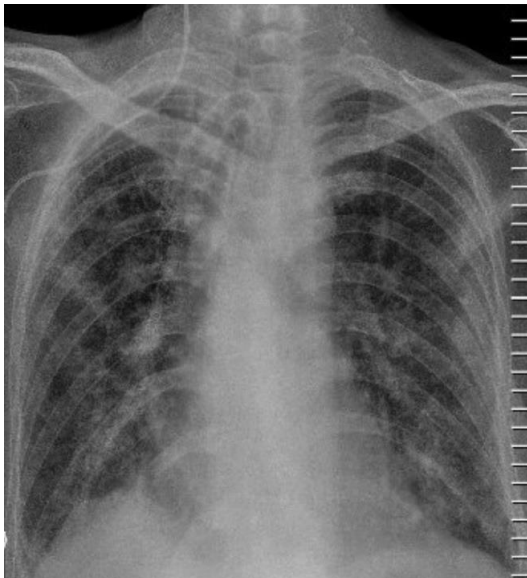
Chest X-Ray (47th Day)
